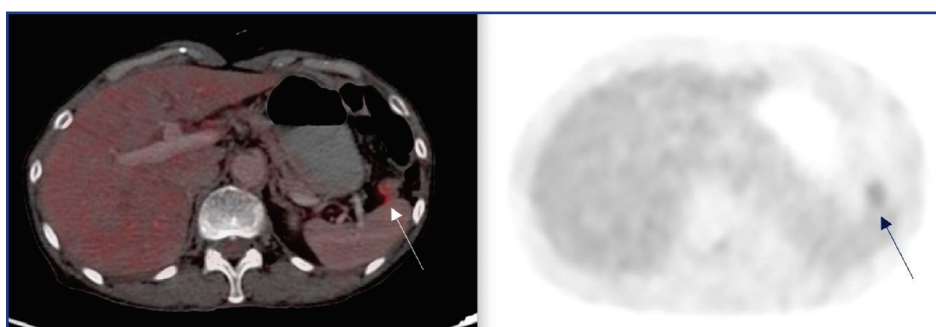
A PET/CT scan from August 2023: reduced metabolic activity in the affected lymph nodes (arrows) indicates a favorable response to second-line chemotherapy
